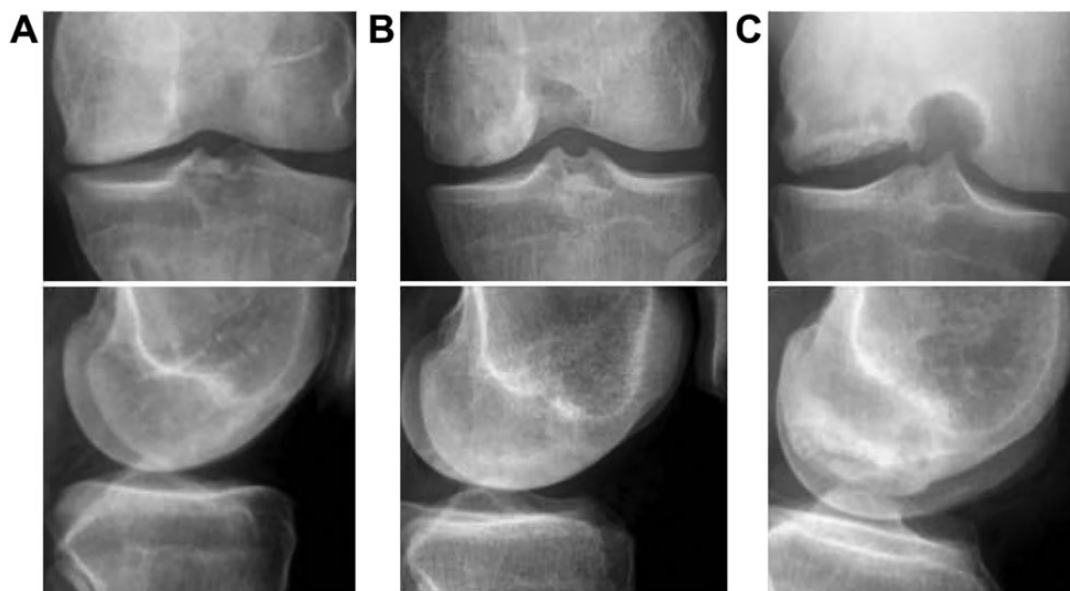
Radiographic incorporation scale of osteochondral allografts on postoperative radiographs. (A) 100% healed: entire graft appears incorporated with no lucency within or surrounding the graft; (B) $\geq 50\%$ incorporation: continuous radiodensity surrounding and within $\geq 50\%$ of graft margins; (C) $< 50\%$ incorporation: continuous radiodensity surrounding and within $< 50\%$ of graft margins.
